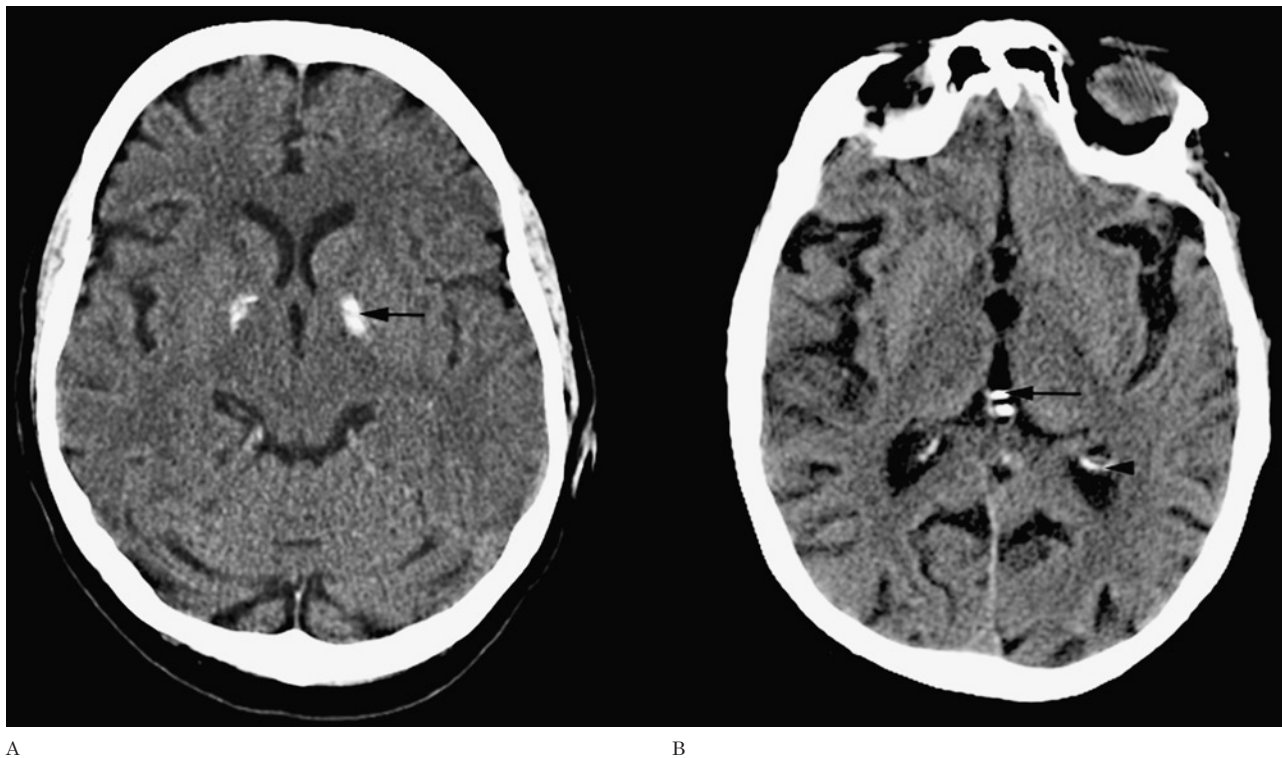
Physiologic calcifications. A) Axial nonenhanced CT shows bilateral basal ganglia calcifications (arrow). B) CT of the same patient at the level of the thalami, shows calcifications of the pineal gland (arrow), the habenula and bilateral choroid plexuses (arrowhead).
